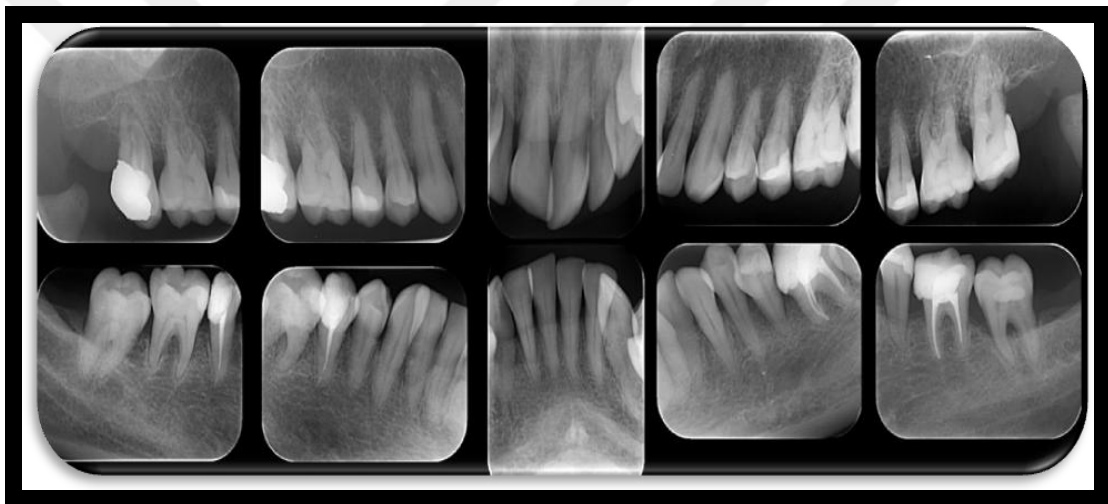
b. Radiographic view
